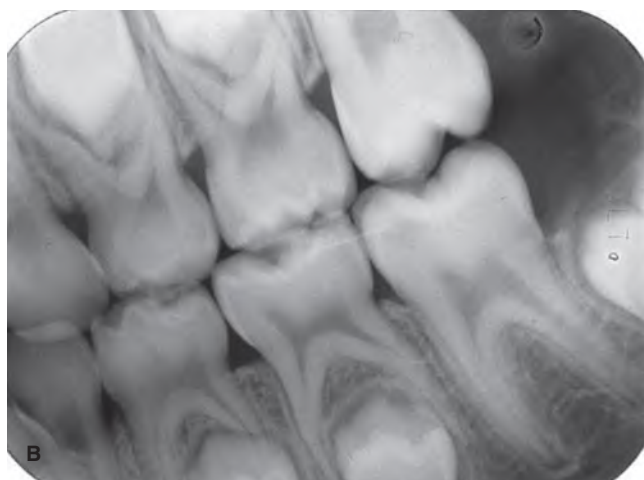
A. Transparent model showing the close relationship between the erupted primary teeth and their developing permanent successors. B. Bite-wing radiograph of the mixed dentition in which the close relationship between the primary teeth and their permanent successors is evident.
